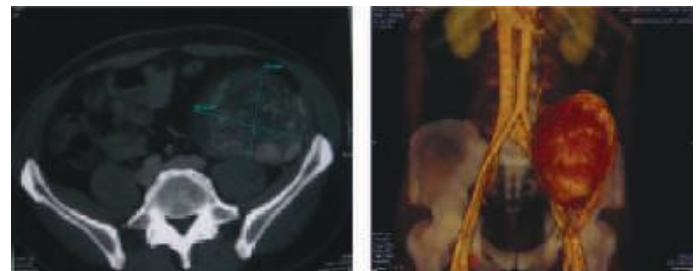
Contrast CT Abdomen with Angiogram – Large Pelvic Tumour with Arterial Supply & Venous Drainage to Common Femoral Vessels
